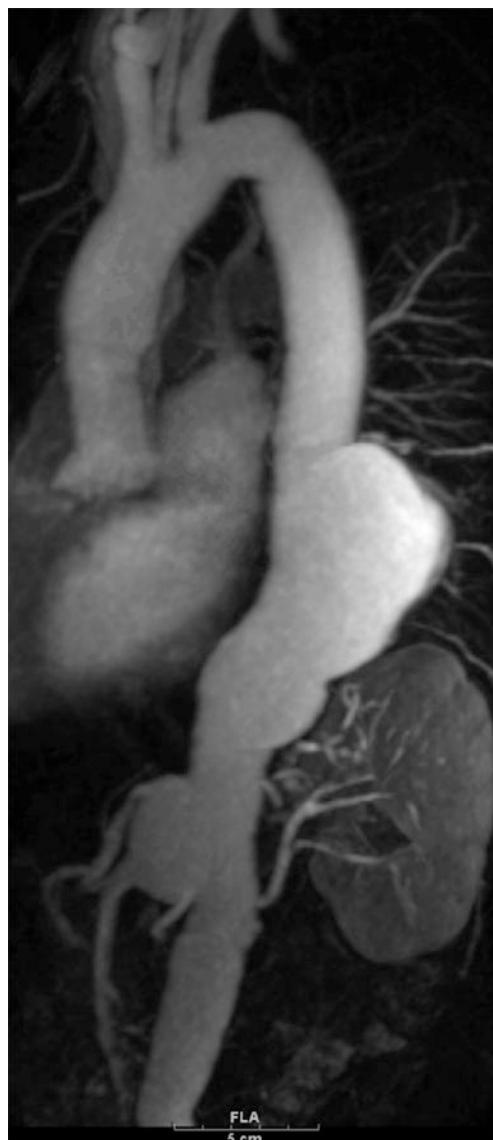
MR image of an aneurysm at the level of the descending thoracic aorta in a 52-year-old lady with Marfan syndrome who underwent previous replacement of the proximal descending and abdominal aorta
